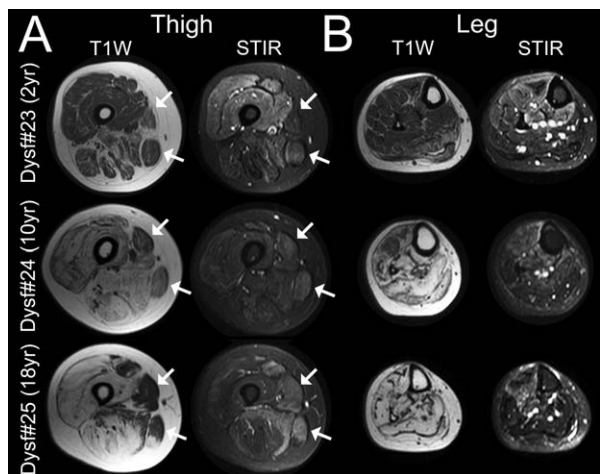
MRI of the Lower Limb. Representative axial T1W and STIR images of thighs (A) and legs (B), of patients in DDG1, 3, and 5. The posterior compartments of legs and thighs are clearly infiltrated by fat early in the disease. Muscles with no fat replacement in the anterior compartments of legs and thighs show edema and reach a similar level of involvement as in the posterior compartment at later stages. The sartorius and gracilis remain relatively spared in the thighs, but as shown in the lower row, at 18 years of disease course, these spared muscles also show edema (arrows). In general, edema tends to decrease with disease progression.
